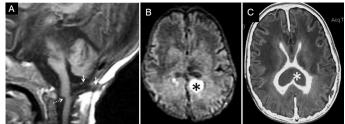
Magnetic resonance images of a 2-month-old girl with cervical DSCI (Case 3). We can identify the subcutaneous and intradural DS tract (white arrows) up to the posteriorside of the bulbo-medullary junction and the partial cervical medullary disconnection with an anterior notch (dotted arrow). In the brain images, the heterogeneous content of the lateral ventricleswith ependymal highlightingdue to pyoventriculitis (asterisks) is observed. A. Sagittal T1 MRI of the craniocervical region. B. Diffusion weighted axial MRI of the brain. C. Axial T1 MRI of the brain with gadolinium.
